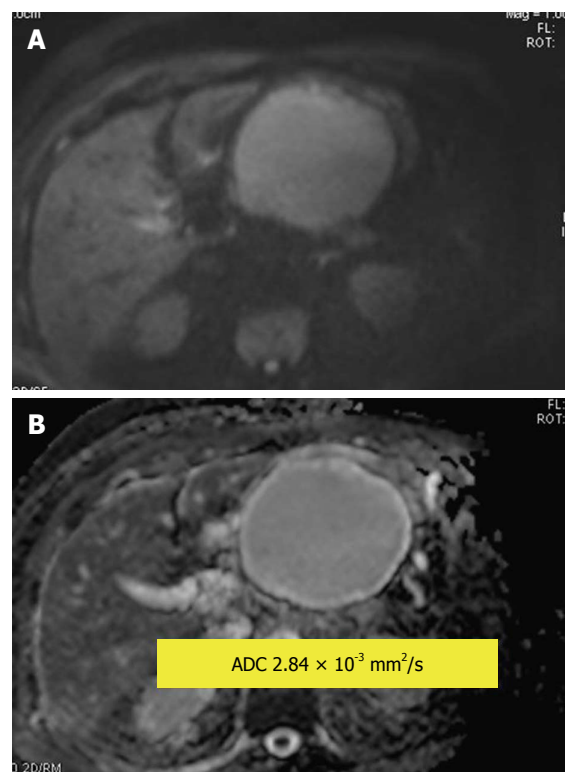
Pancreatic pseudocyst. A: Diffusion-weighted image (DWI); B: Apparent diffusion coefficient (ADC) map. Hyperintensity of the cyst on DWI is due to the T2 shine through effect. Measured lesion ADC = $2.84 \times 10^{-3} \text{ mm}^2/\text{s}$. The reference for the fluid in this study (cerebrospinal fluid) was ADC = $4.06 \times 10^{-3} \text{ mm}^2/\text{s}$.
